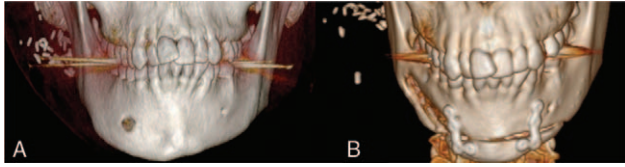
Three-dimensional computed tomography reconstruction of the patient facial skeleton. (A) Before surgical treatment. (B) After surgical treatment.
